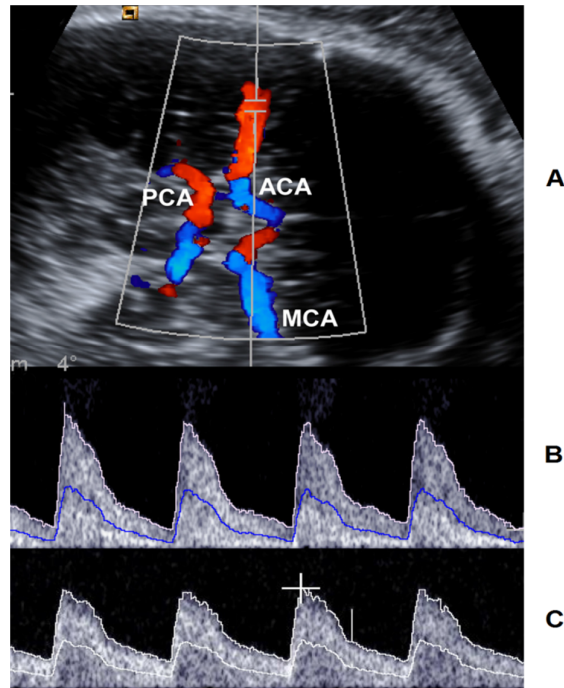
A, Color Doppler assessment of the MCA at the level of the circle of Willis. B, Normal and abnormal (high diastolic velocities and decreased pulsatility index) C, waveforms are shown. *ACA*, anterior cerebral artery; *MCA*, middle cerebral artery; *PCA*, posterior cerebral artery.
